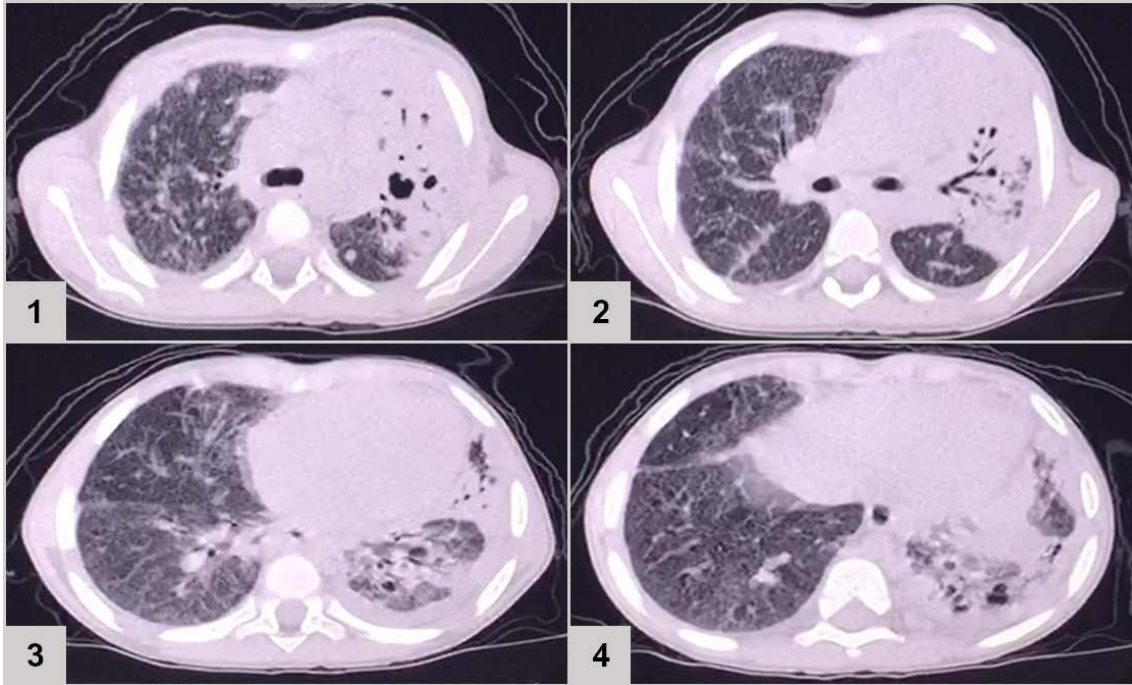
CT of the chest results: extensive consolidation, with air bronchograms and cystic images in between, in the left lung (3 and 4); ground-glass opacities, diffusion in the lower left lobe (1 and 2); nodular opacity, no sign of calcification in between, on both lungs (1, 2 and 3); reticular and linear opacity and parenchymal bands in the upper lobes (3 and 4); small pleural effusion on the left (1 and 2); adjacent subsegmental atelectasis (2 and 4)
